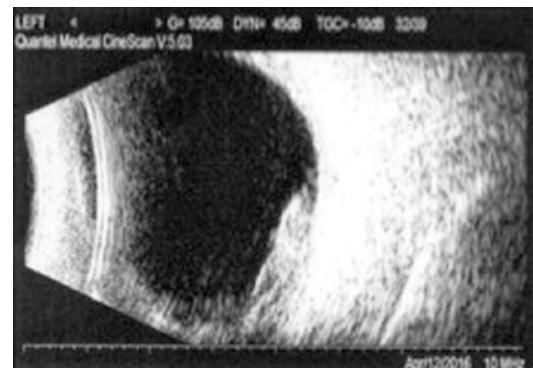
Ocular ultrasonography B-scan demonstrating an abnormal echo on the inferior nasal side of the eyeball at the fifth day after the primary surgery
